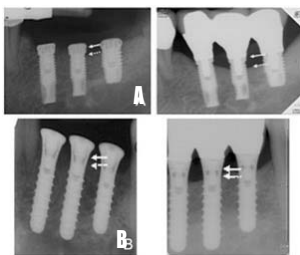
Periapical radiographs of implants. (A) Submerged implant (Left: the day of surgery, Right: 6.4 years after implant placement). Marginal bone loss of distal side of #36 implant was 1.41 mm. (B) Non-submerged implant. Marginal bone loss of distal side of #33 implant was not occurred (Left: the day of surgery, Right: 7 years after implant placement). (arrow: reference point, dotted arrow: most coronal point of bone to implant contact).
